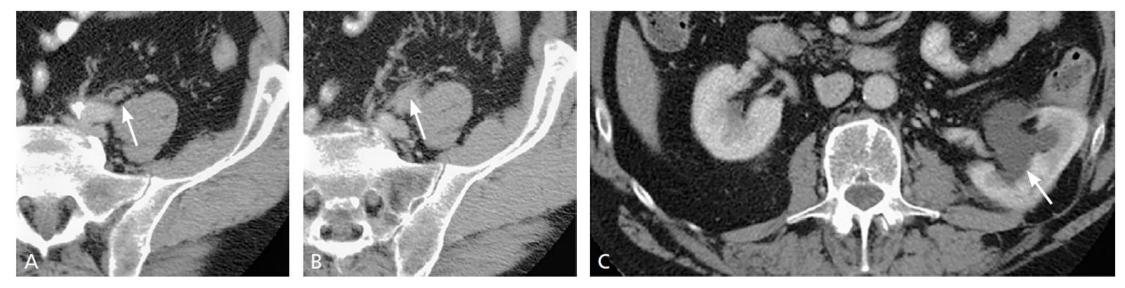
(A and B) Multiphasic computed tomography urography in a 53-year-old man with hematuria secondary to a transitional cell carcinoma of the left ureter shows thickened, enhancing ureteric wall (arrow) with periureteric fat stranding (arrow) suggestive of a urothelial lesion with extramural spread of the disease. (C) Proximal hydronephrosis with hydroureter (arrow) is noted.
